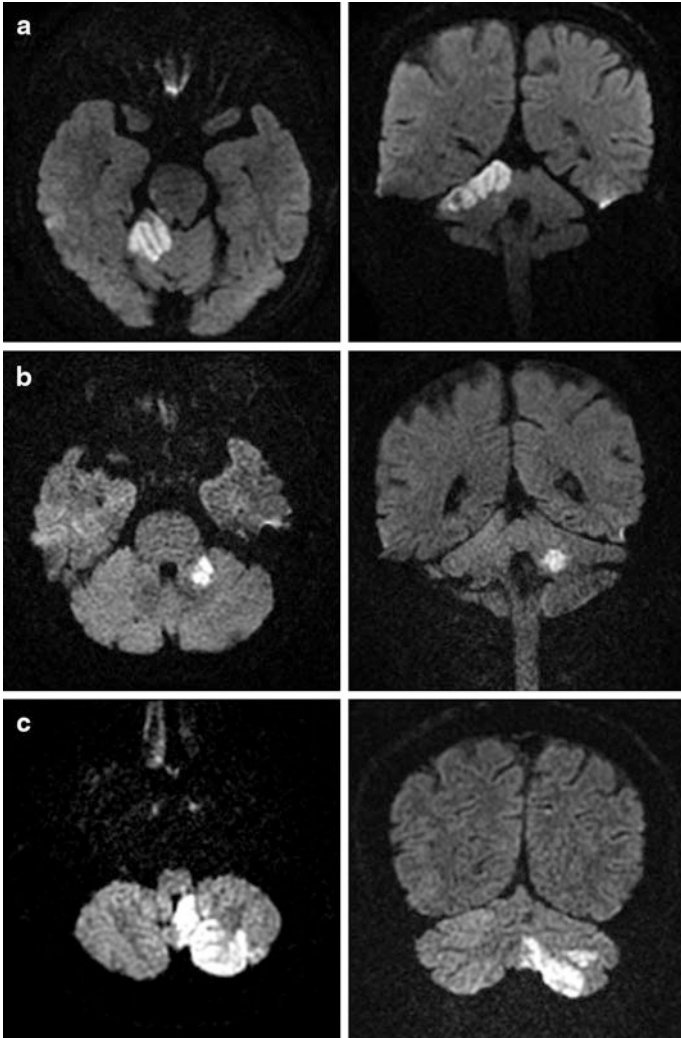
Cerebellar territorial infarctions. Representative diffusion-weighted magnetic resonance images demonstrate the topography of SCA (a), AICA (b), and PICA infarction (c)
